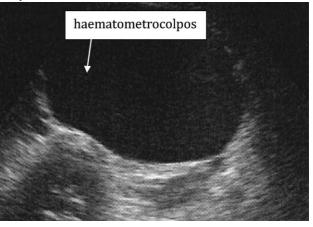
Picture of Pelvic ultrasound after urinary catheterization
